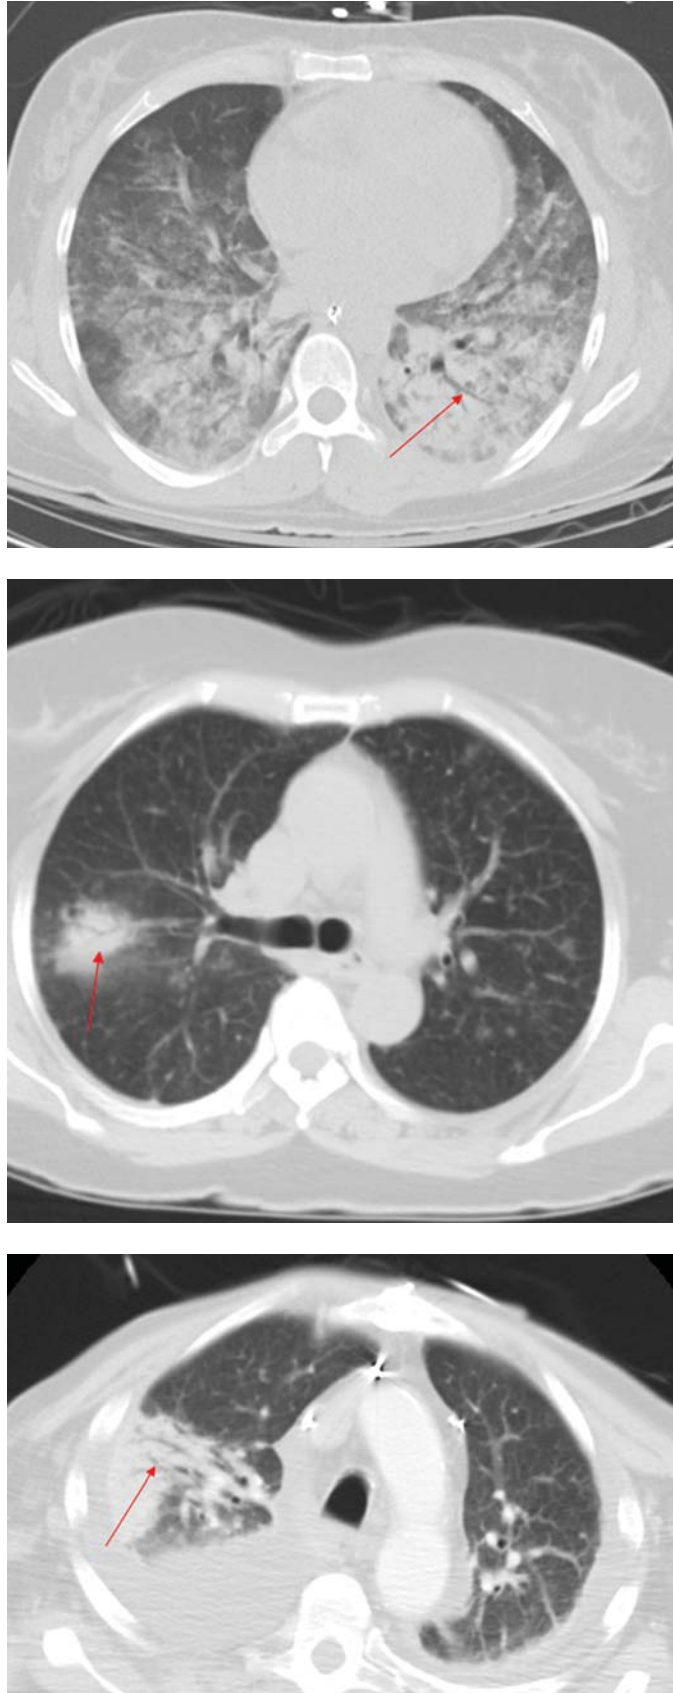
FIGURE e24-30 Three examples of air bronchograms (red arrows) on chest CT.
